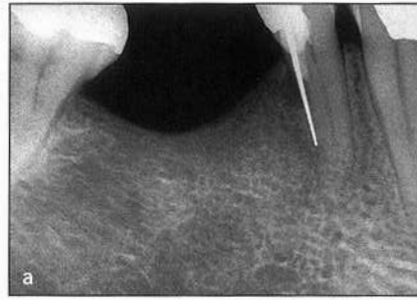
(a) Preoperative radiograph of a mandibular premolar with coronal root perforation. (b) Radiograph taken after removal of a silver point from the perforation site and locating of the root canal. (c) Postoperative radiograph after completion of root canal treatment. (d) Postoperative radiograph after repair of the coronal perforation with amalgam.
